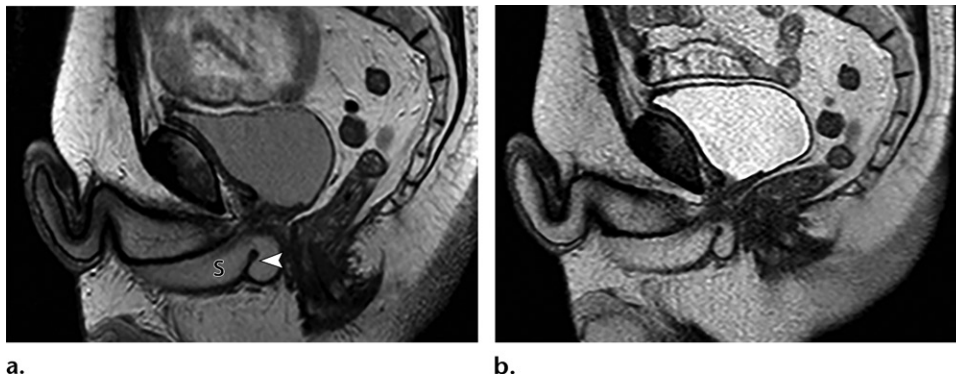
Urethral sling in a 70-year-old man (same patient as in Fig 21). (a) Sagittal T2-weighted image with the patient at rest shows the positioning of the sling (S) below the urethral bulb, with a slight indentation (arrowhead). When it is tensioned appropriately, the sling elevates the urethral bulb 2–4 cm into the pelvis and provides support to the distal membranous urethra. (b) Sagittal T2-weighted image shows the patient during increased abdominal pressure, which facilitates continence during stress. Note the cushion of healthy spongy tissue between the sling and the distal sphincteric urethra. In cases of sling failure or sling-related injury, one can see atrophy or focal thinning of this tissue (not shown).
